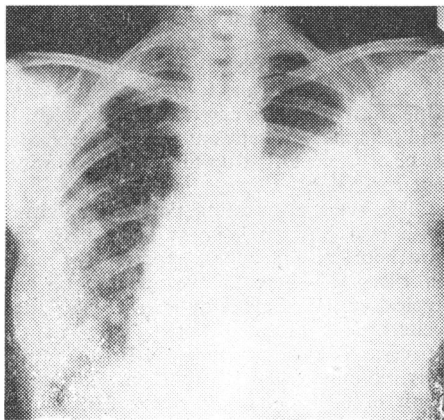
Chest x-ray prior to treatment—large effusion and pulmonary metastases.
